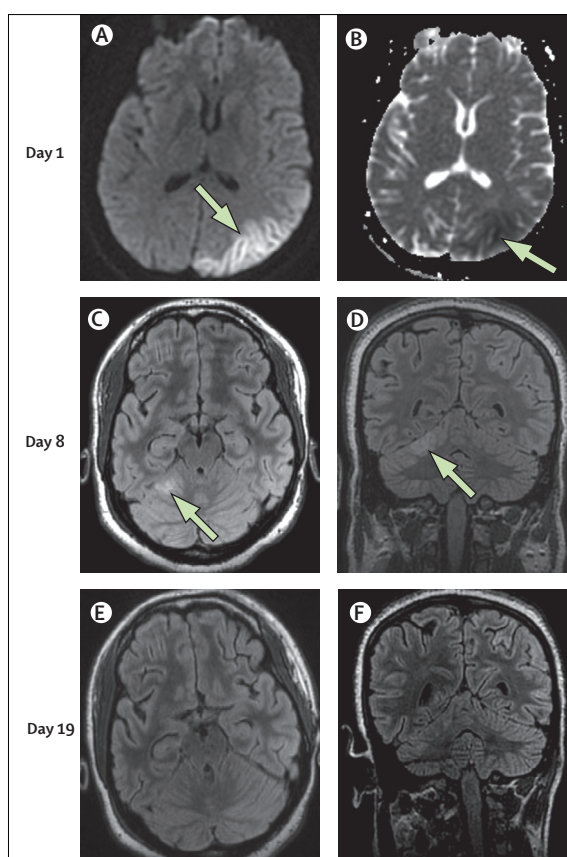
MRI of a single patient with focal left hemispheric status epilepticus during a single admission to hospital
